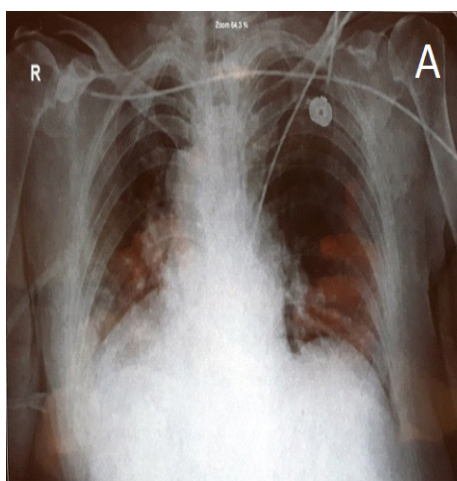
(A): Radiography of thoracic part of the patient (B): An abdominal computed tomography revealed transposition of the visceral organs from the right to left side and microlithiasis in the dilated common bile duct.
